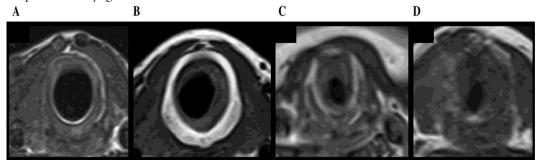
Staging of SGS using MRI technique (29).
